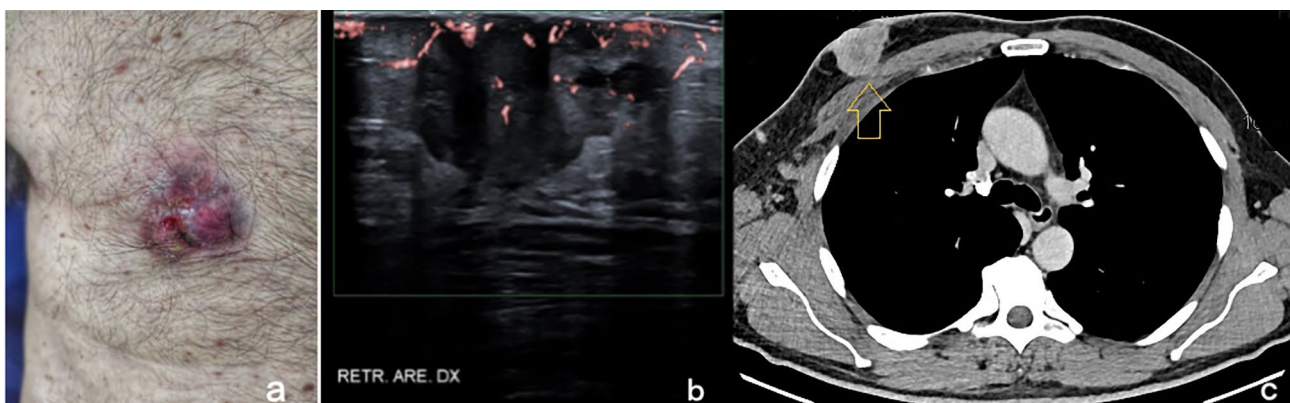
a Invasive ductal carcinoma, on ultrasound, (b) the lesion is hypoechoic and ill-defined, with irregular borders and internal vascularity at the color Doppler. c Confirmed at the MSCT, the infiltration of the muscle
